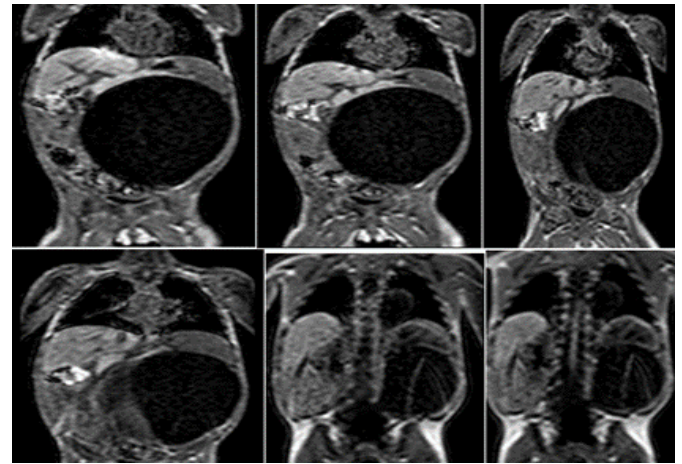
Axial T1-weighted images showing a left-sided hypointense cystic lesion communicating with the spinal subarachnoid space
